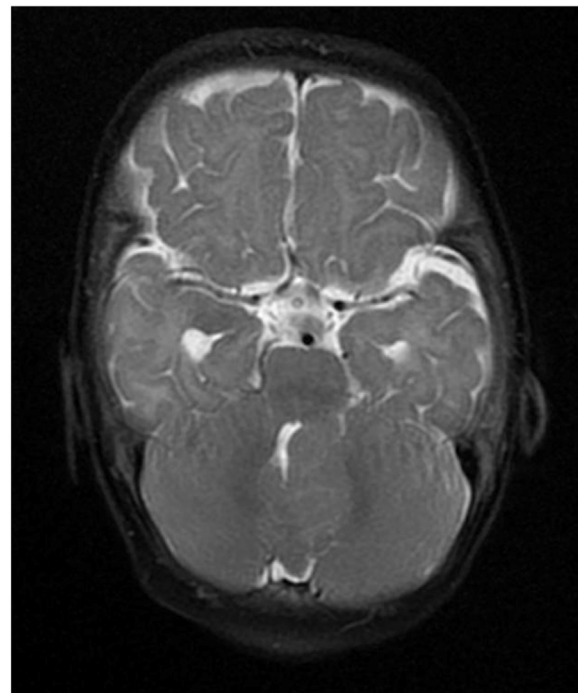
Preoperative axial T2 MRI of the left-centered HFFV involving the cerebellum.
